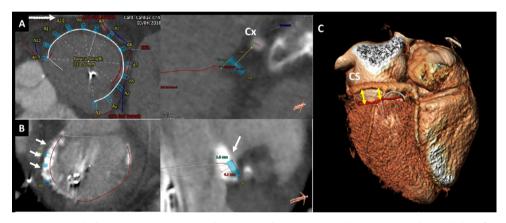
Multidetector row computed tomography to assess the anatomical suitability for transcatheter mitral valve annuloplasty. Panel a demonstrates a patient suitable for Cardioband. The left part shows the anchoring planning (arrow) in the mitral valve annulus. At the right is the distance measured between the anchoring and annulus (4.0 mm) and distance between anchoring and circumflex coronary artery (Cx, 7.6 mm). Panel b shows an example of a patient with unsuitable anatomy for Cardioband with massive mitral annulus calcification (arrows). In the left the anchoring would be in the calcified mitral valve annulus at the level of P1 (arrow). For indirect transcatheter mitral annuloplasty technique, the distance between the coronary sinus and the mitral annulus is relevant to efficiently reduce the size of the annulus. From three-dimensional volume rendering, the coronary sinus can be visualized coursing in this patient too high above the mitral annulus (line) as pointed out by the double arrowheads (panel C).
